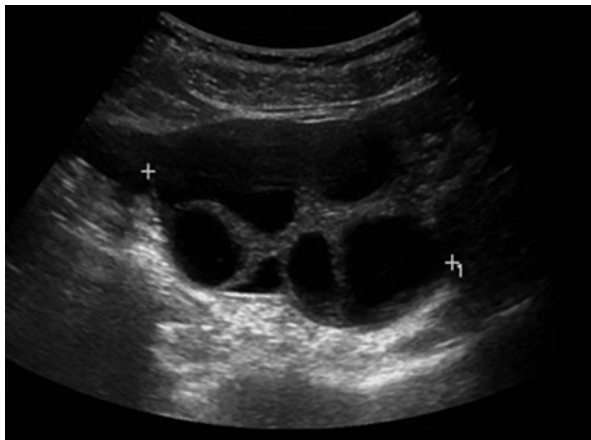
Hyperstimulated ovaries. Transvaginal ultrasound reveals bilaterally enlarged multicystic ovaries (8 cm) in a patient undergoing controlled ovarian hyperstimulation
